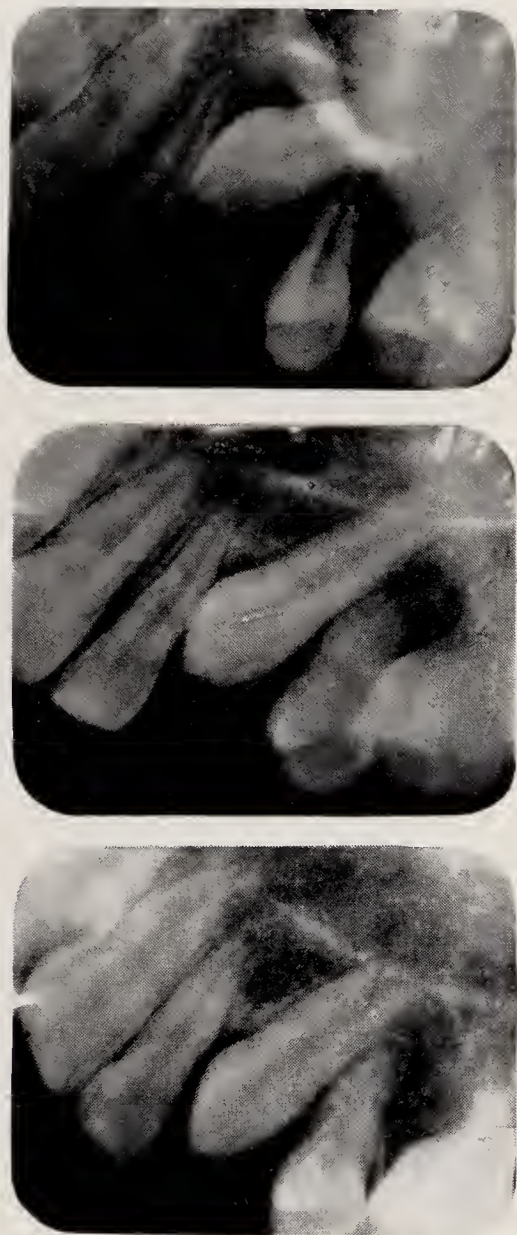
A series of radiographs showing the movement of $\underline{3}$ in patient between 7 and 12 years of age in which $\underline{3}$ has moved into position after the extraction of $\underline{C4}$.
